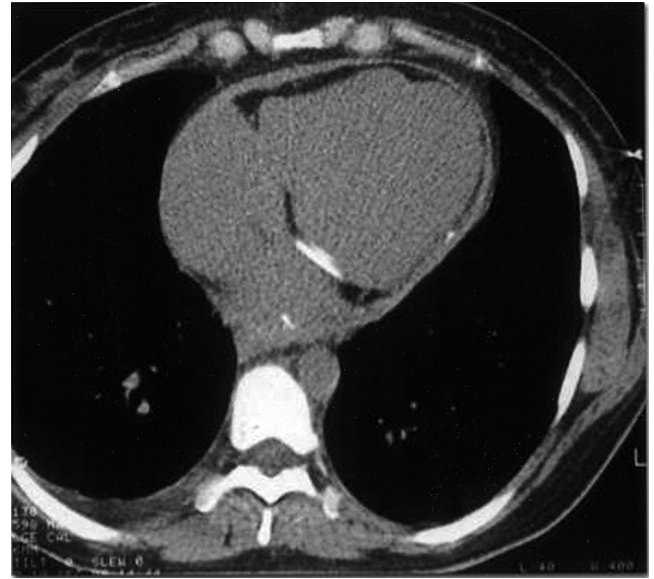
CT scan showing increased pericardial thickness and mild calcification in a patient with constrictive pericarditis.
